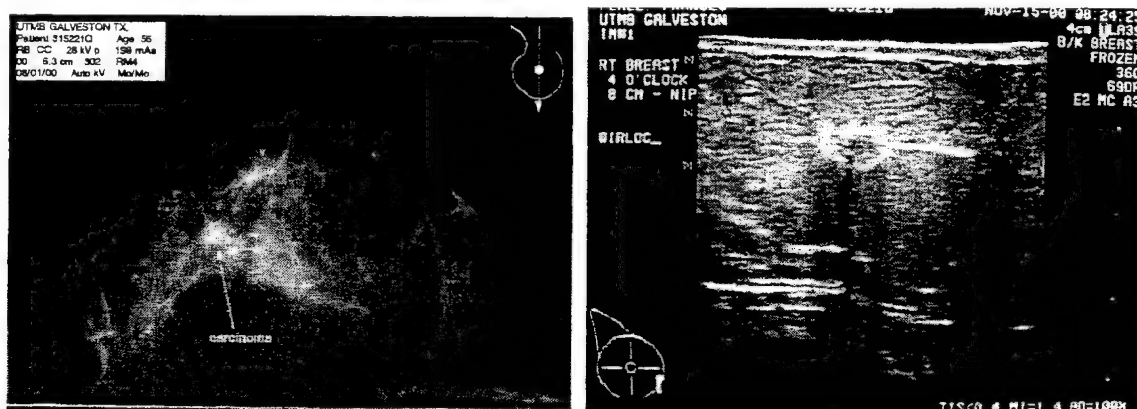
X-ray mammography image of a cancerous breast (left). There were 2 suspicious areas on mammogram, only one of them was a ductal carcinoma. Ultrasound image of the same breast showing malignant tumor. UTMB Patient # 315221.
